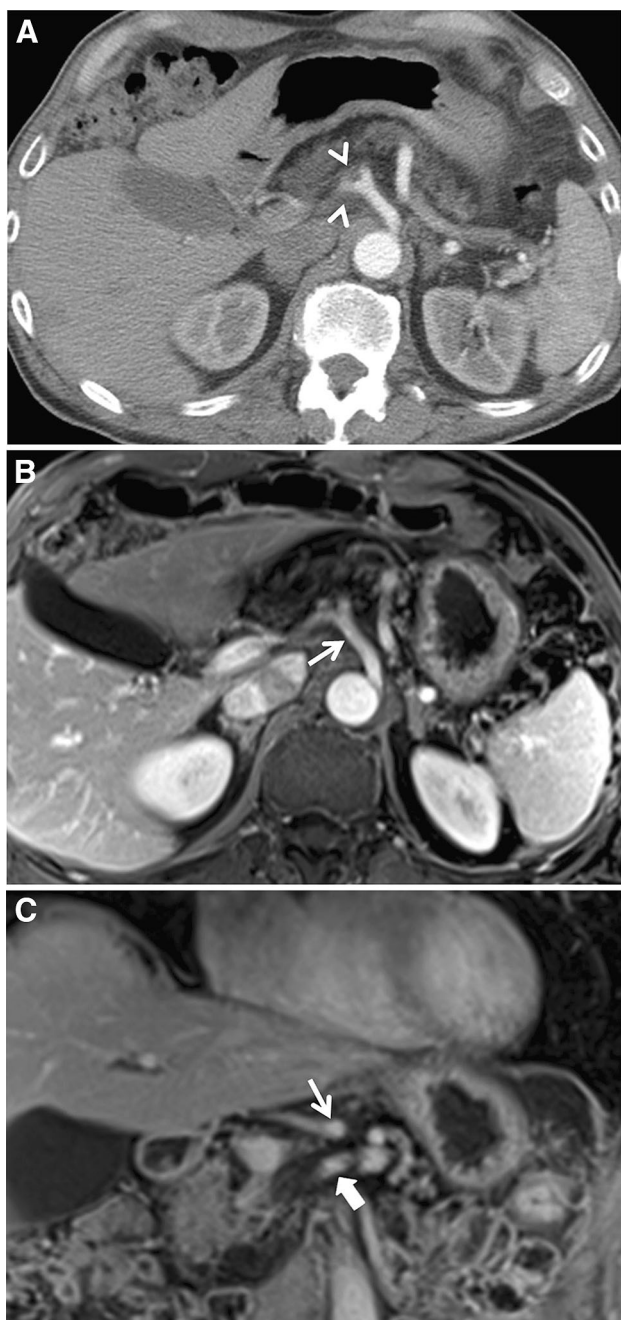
Axial contrast-enhanced CT image (A) in a patient with a known pancreatic head tumor (not shown) demonstrating ill-defined density around the celiac bifurcation (arrowheads), suspicious for tumor involvement. Axial (B) and coronal (C) T1 weighted post-contrast images of a subsequent MR exam 4 weeks later with no interval treatment demonstrate no tumor involvement about the celiac axis (thin arrow) or SMA (block arrow). This patient proceeded to pancreaticoduodenectomy with negative surgical margins.
